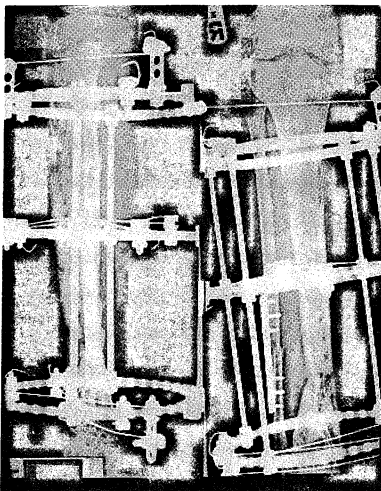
Anteroposterior and lateral roentgenogram showing the intercalary segment has approached the target segment and distraction osteogenesis occurred.
